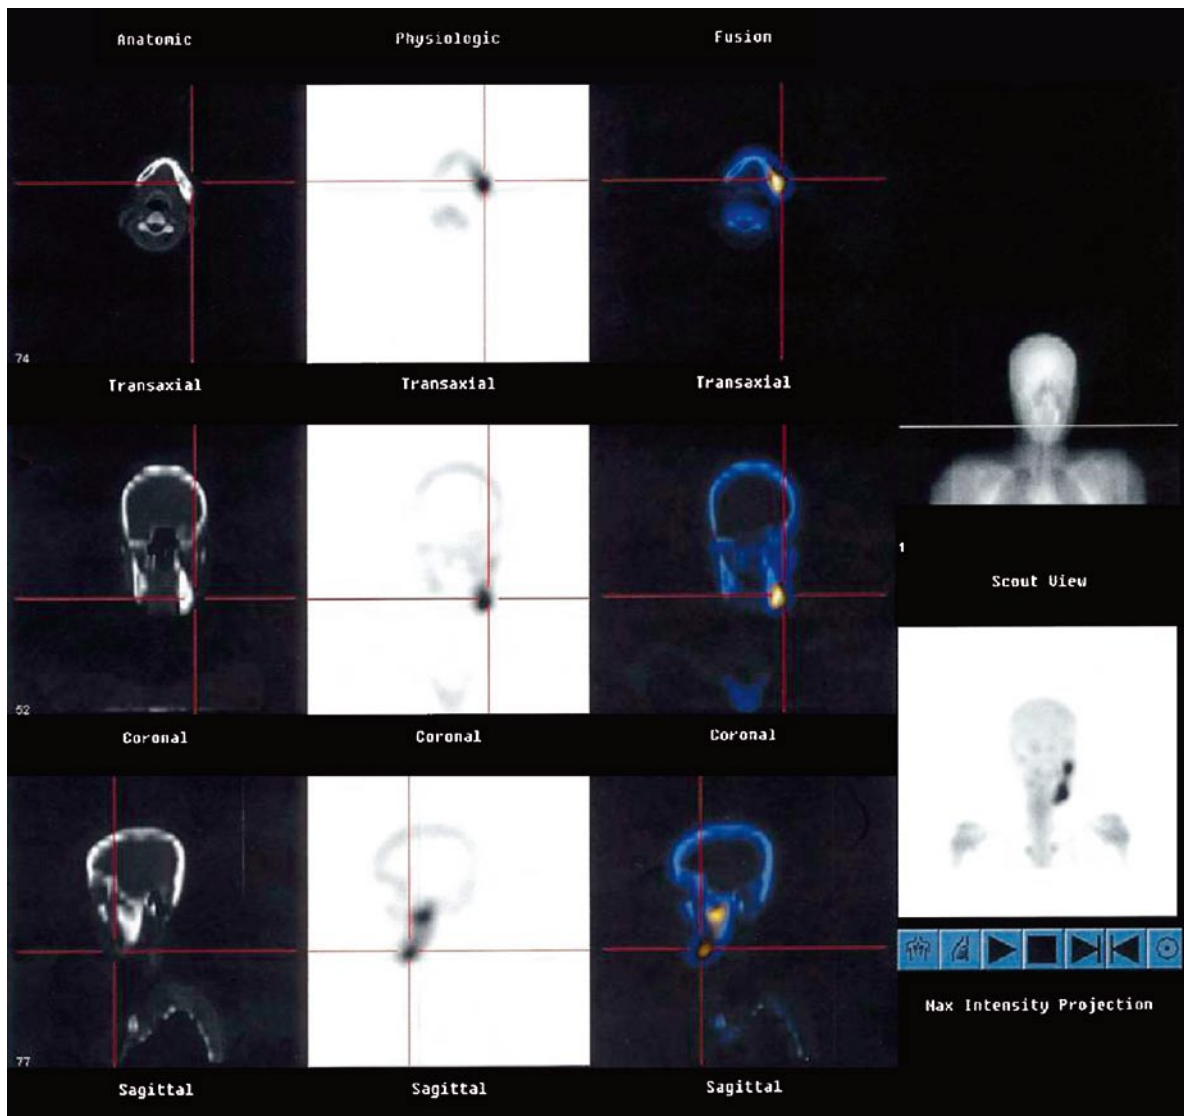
Combined ^{18}F FDG PET/CT scan of a patient with primary chronic osteomyelitis of the mandible. The hybrid scan allows the exact anatomical outlining of the affected region with an increased metabolic activity. The
